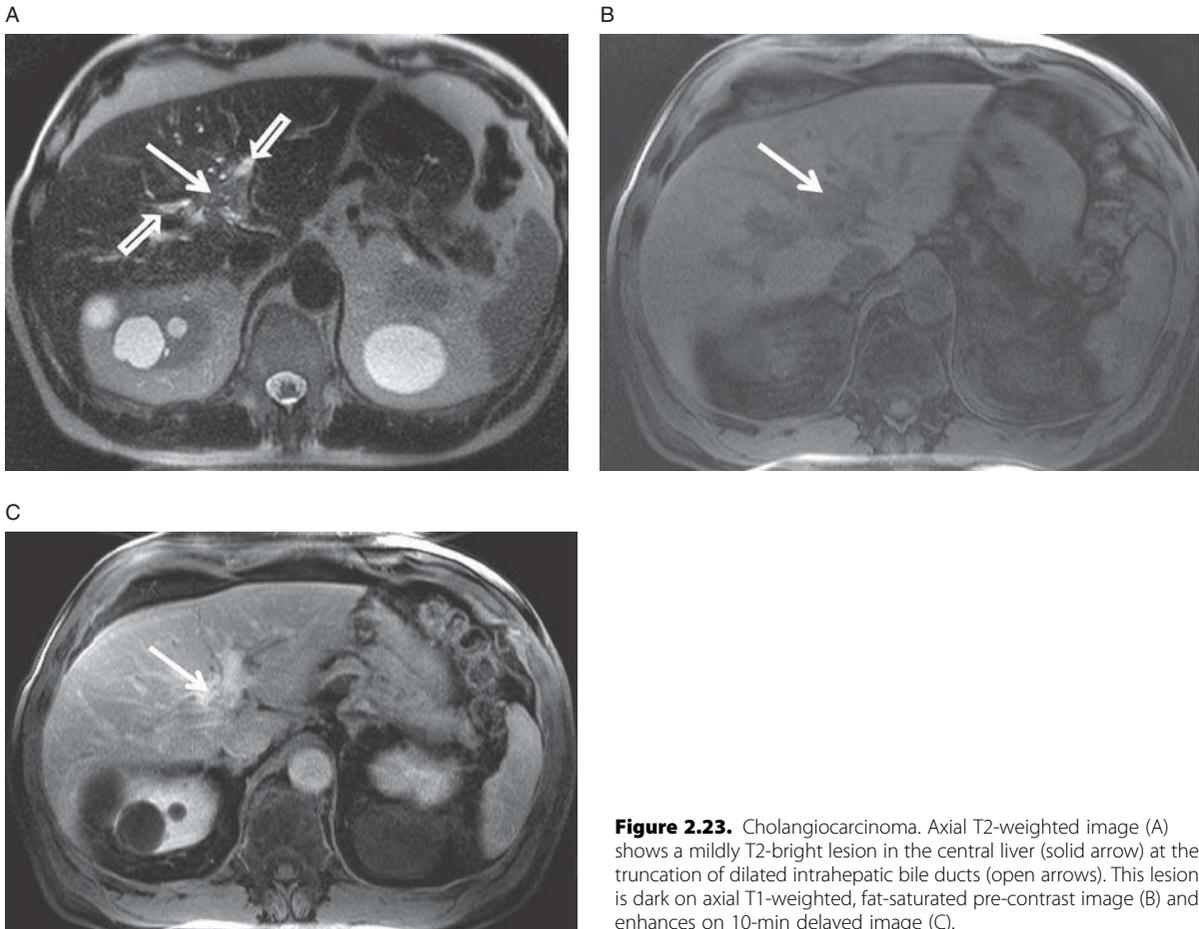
Cholangiocarcinoma. Axial T2-weighted image (A) shows a mildly T2-bright lesion in the central liver (solid arrow) at the truncation of dilated intrahepatic bile ducts (open arrows). This lesion is dark on axial T1-weighted, fat-saturated pre-contrast image (B) and enhances on 10-min delayed image (C).
